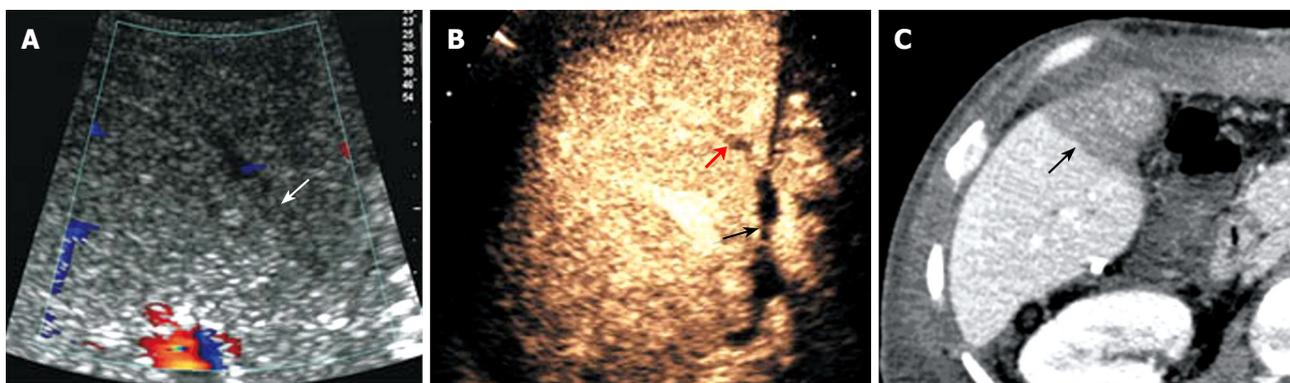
Color Doppler sonography showing MHV tributaries filled with hypoechoic substances representing thrombus (arrow) with no color signal in vessel grafts (A), contrast enhanced sonography showing no contrast agent in vessel grafts (arrow) and MHV tributaries (red arrow) indicating vessel occlusion (B), and contrast enhanced CT scan on postoperative day 2 showing an area of low attenuation in segment V corresponding to the draining territory of MHV (arrow) (C) in a 42-years old male who received a modified right lobe graft from his brother.
